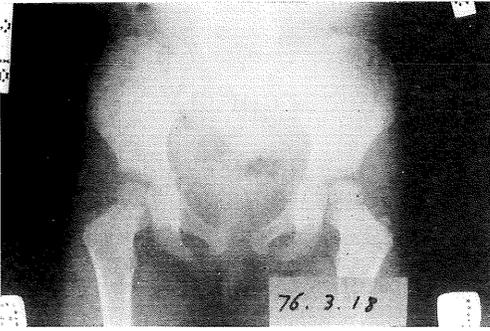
X-Ray of the pelvis taken on March 18, 1976.
